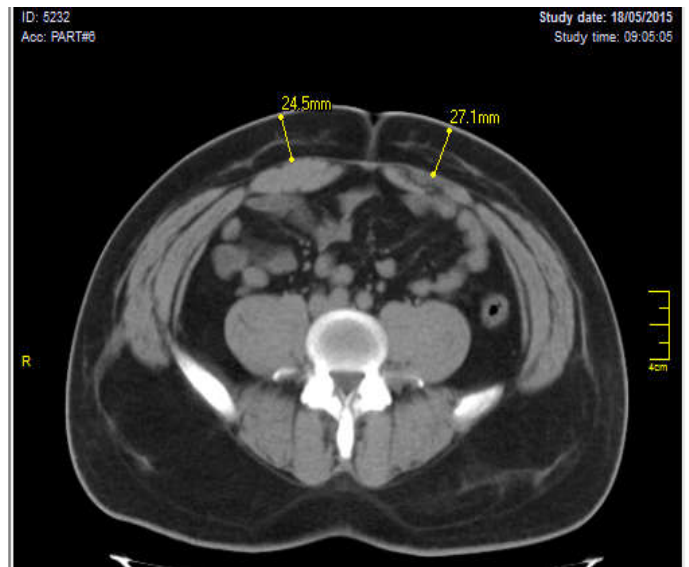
Patient caliper measurement was 4 cm, related to 24.5 and 27.7 mm CT scan measurements
